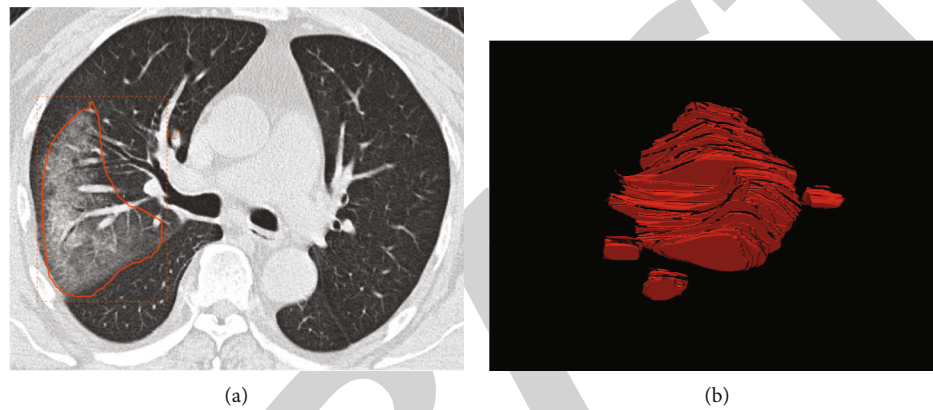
A case of confirmed mild COVID-19. A 63-year-old male presented with a 5-day history of fever, cough, and mild dyspnea. (a) CT imaging revealed pure GGO with distribution in the left lower lobe. The area of the lesions was delineated on the axial. (b) The reconstructed images.
